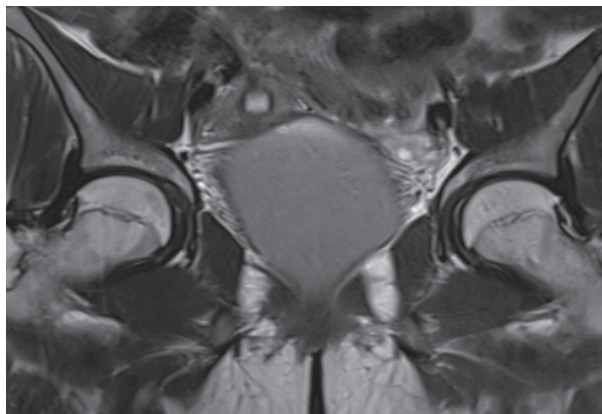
T2 Weighted MRI, COR
